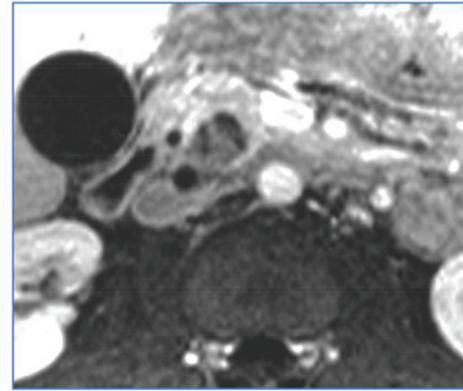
Contrast enhanced T1-weighted magnetic resonance image demonstrating a hypoenhancing low-intensity mass in the posterior aspect of the pancreatic head, abutting the distal part of the common bile duct.
